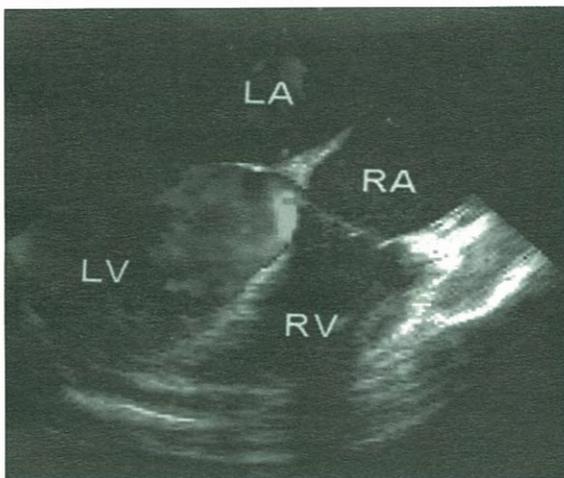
Intraoperative transesophageal echocardiogram of the patient following surgical repair demonstrates complete repair of the defects. LV: left ventricle, LA: left atrium, RV: right ventricle, RA: right atrium.
